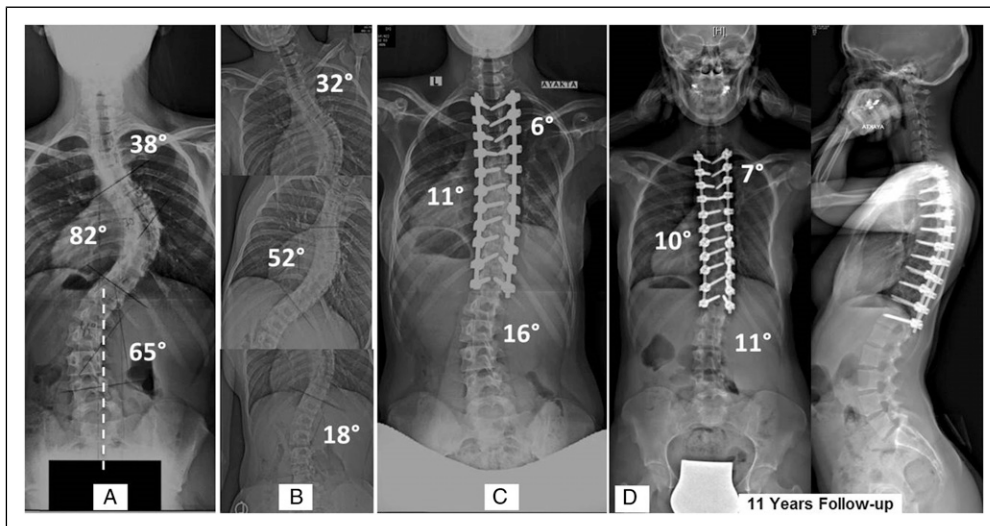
15 years female patient. A: Preop AP Standing X-ray; B: Bending X-rays; C: Early-postop AP Standing X-ray; D: 11 years Follow-up AP and LAT Standing X-rays; AP: Anteroposterior; LAT: Lateral.
